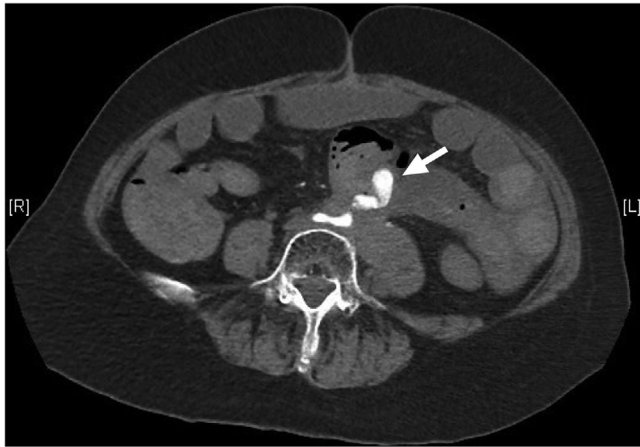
Computed tomography angiography showed a fistula connecting jejunal lumen and left common iliac artery, with contrast extravasation in the jejunum
